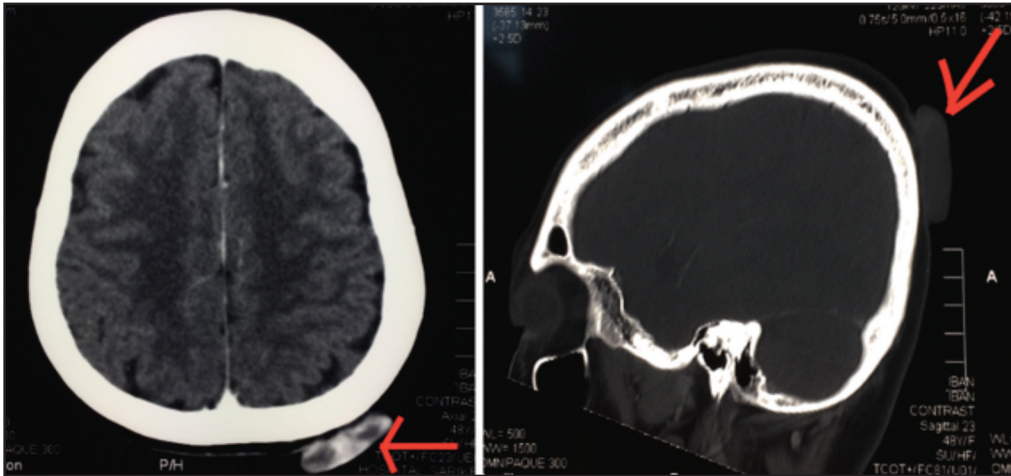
CT scan showing a solid mass 4x4x1cm(arrow) with no cranial vault extension
